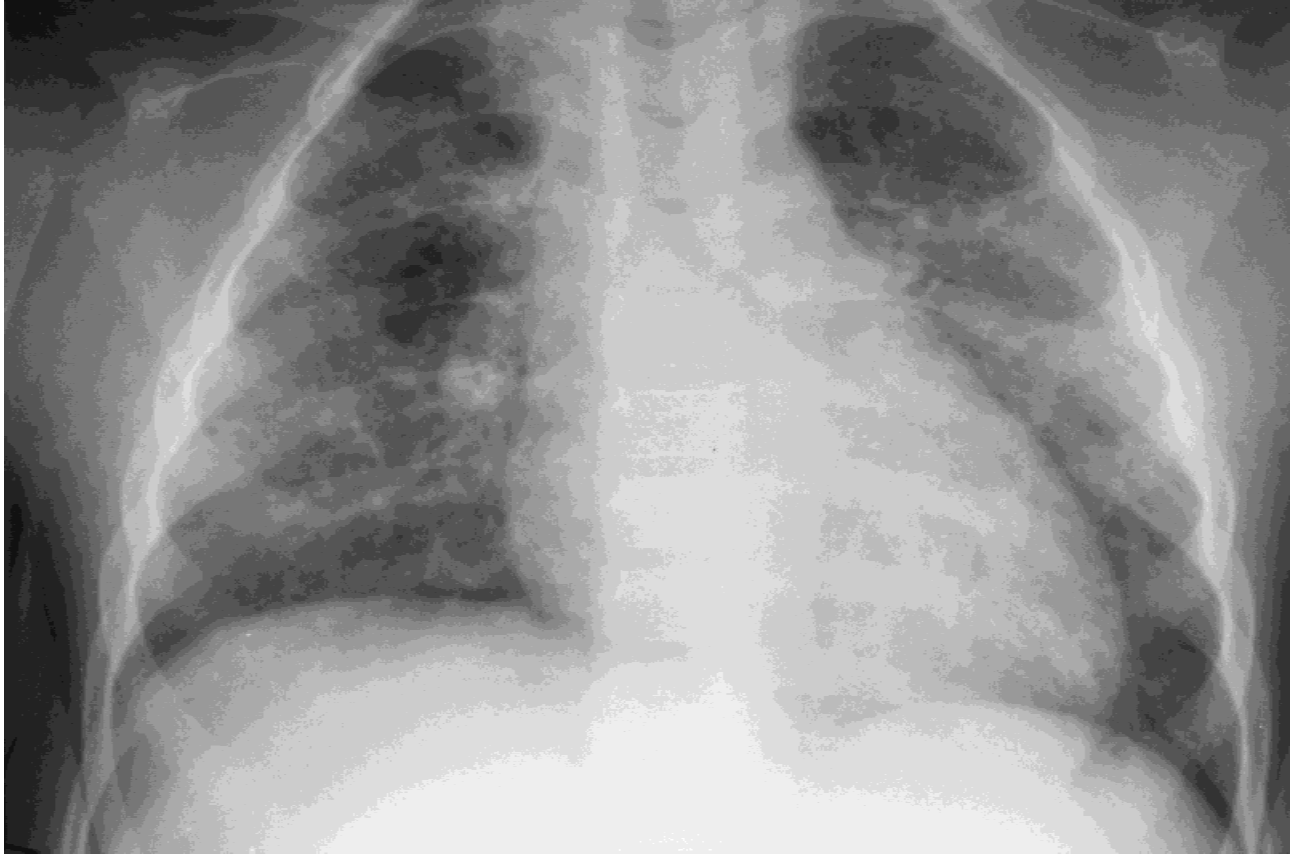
Age 2 years, 8 months. Chest radiograph shows marked improvement with persistence of only a small bulla in the right lung.
